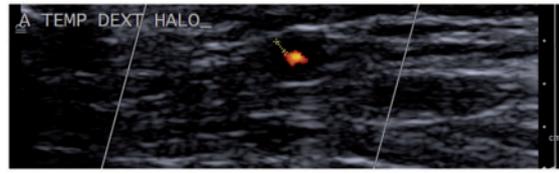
Giant cell arteritis: colour Doppler image of an inflamed temporal artery. The black region surrounding the red zone in the image shows the characteristic « halo sign ».
